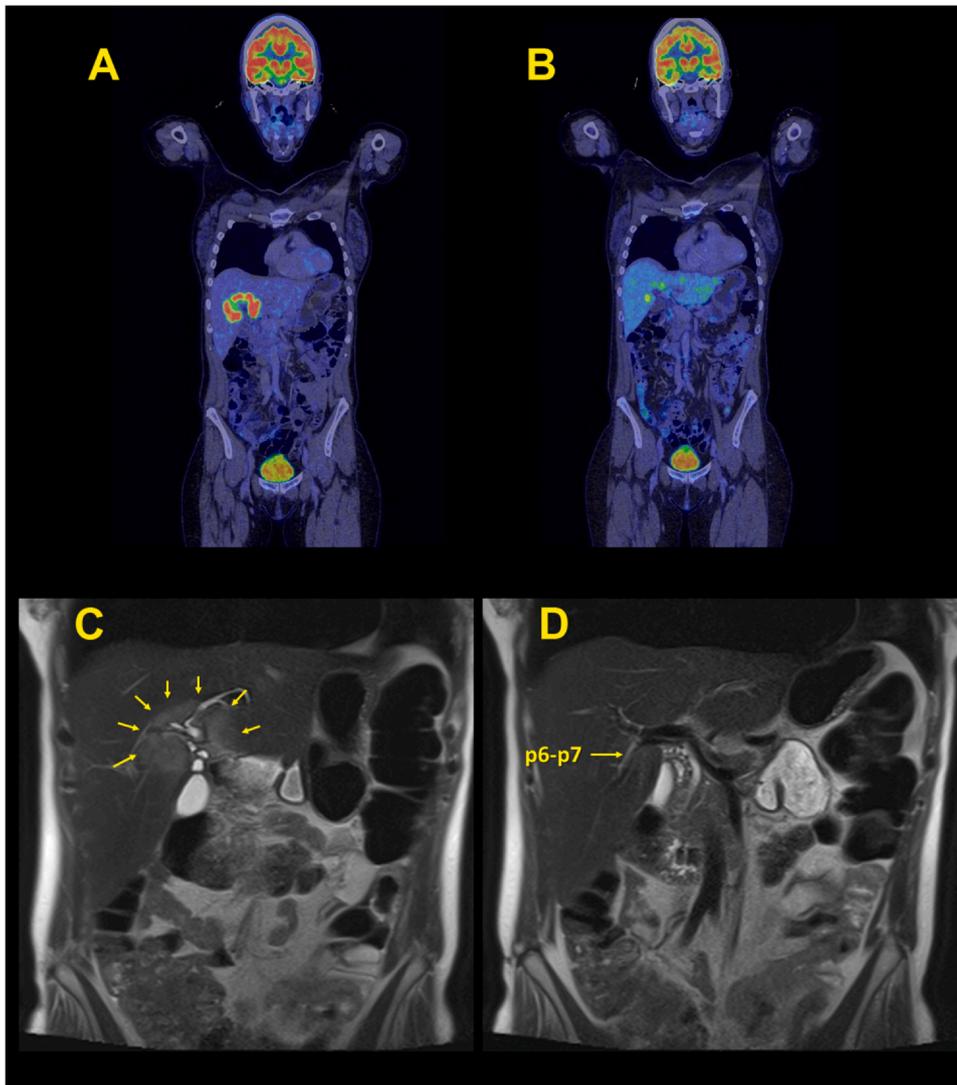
Robotic left trisectionectomy. Preoperative imaging examination. A, PET-CT before neoadjuvant treatment. Imaging shows a single tumor confined to the liver. B, PET-CT after neoadjuvant treatment. Imaging shows a significant decrease in tumor activity. C, MRI showed a unique and large tumor encompassing the hilar plate. D, MRI shows that the posterior pedicle is preserved. MRI, magnetic resonance imaging; PET-CT, positron emission tomography–computed tomography.
